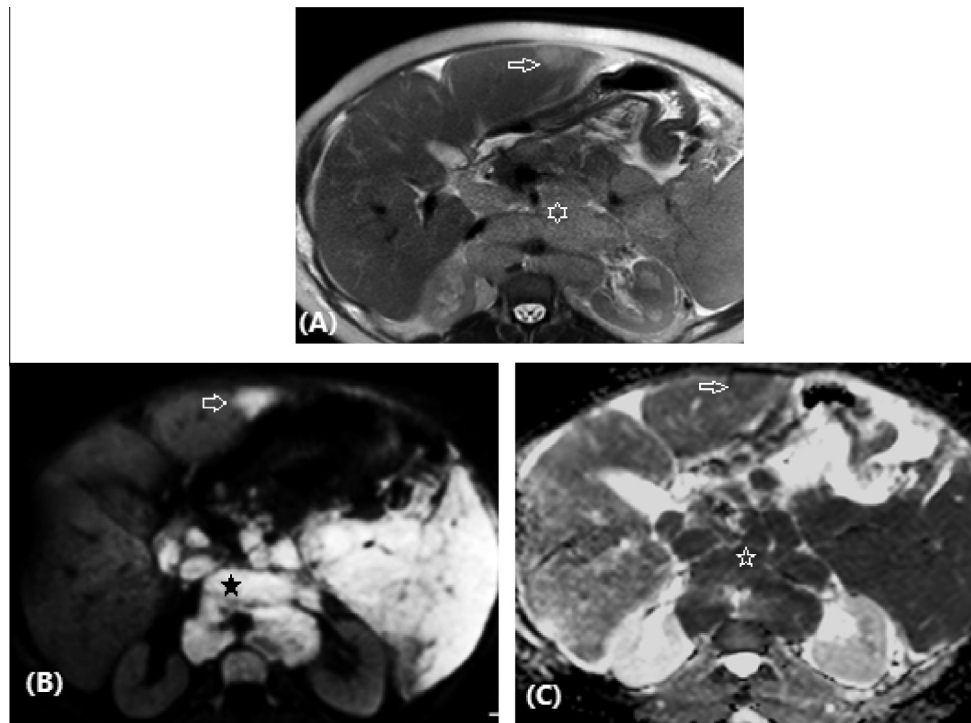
Lymphoma in a 28 year-old female patient (A) Axial T2-weighted image displays an ill-defined slight hyperintense left lobe focal lesion (arrow). Note the associated multiple enlarged paraortic and porta hepatis lymph nodes (asterisk). (B) DWI ($b = 600$) image shows obviously the hyperintense hepatic lesion (arrow) and the enlarged lymph nodes (asterisk). (C) On the ADC map, both hepatic lesion (arrow) and lymph nodes (asterisk) are hypointense with low ADC value ($1.1 \times 10^{-3} \text{ mm}^2/\text{s}$).
